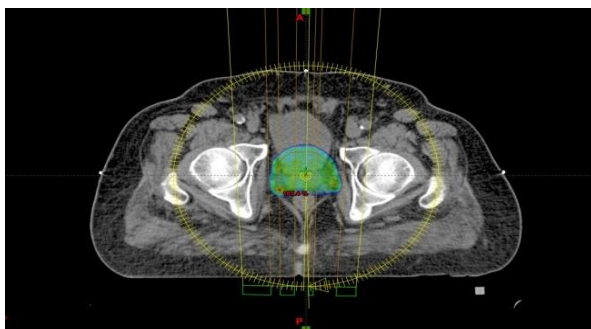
presents an axial computed tomography slice showing dose coverage for the VMAT plan.
